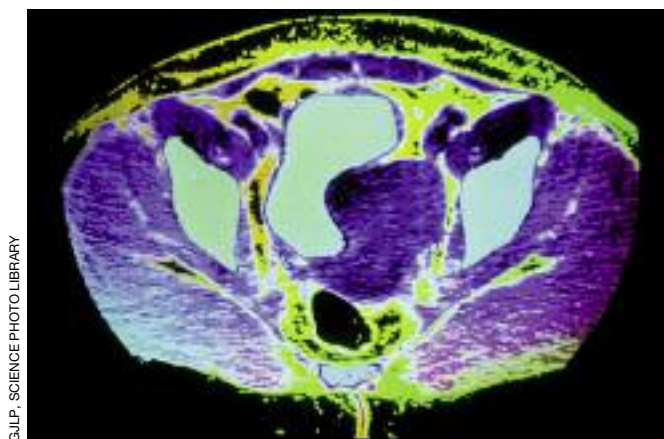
Coloured CT scan through a woman's lower abdomen showing a large fibroid (centre, dark blue) pressing against the bladder (top centre, light blue). To the left and right of the fibroid are the pelvic bones (also light blue) and below it is the lumen of the uterus (black circle). The yellow areas are uterine wall.
